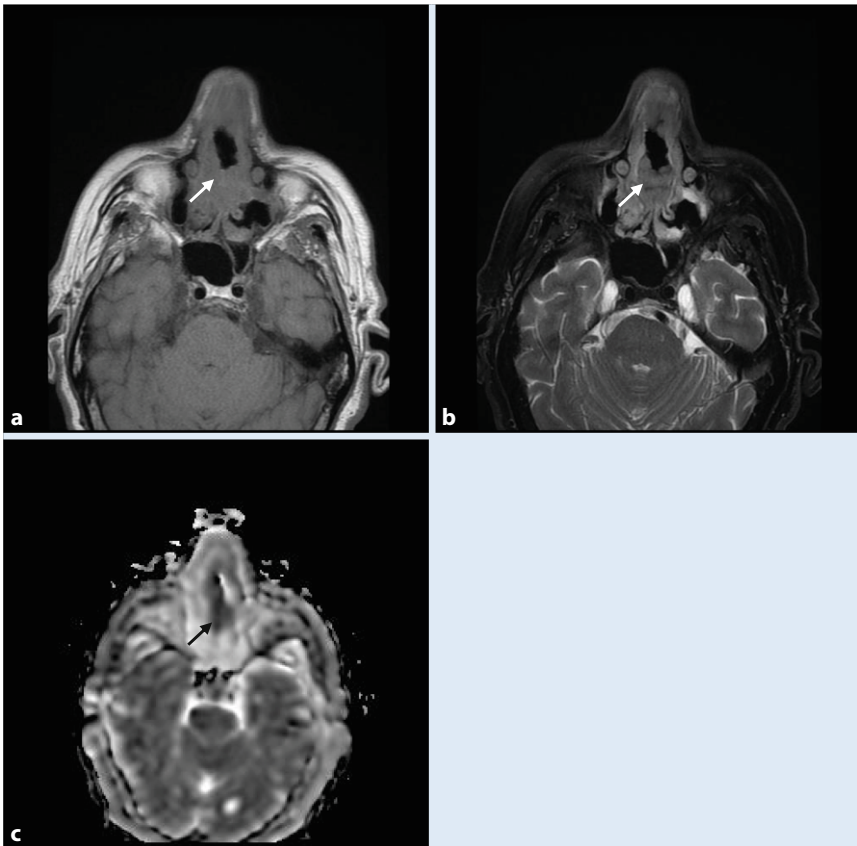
◀ The maxillofacial magnetic resonance image (MRI) of the patients. *White arrows* show a minimally enhancing mass after low-signal IV contrast agent in T1 (a) and T2 (b) sequences. The mass was obliterating the nasal passage in the perpendicular lamina. The *black arrow* depicts marked diffusion restriction (apparent diffusion coefficient: 0.6×10^{-3} ; c)
